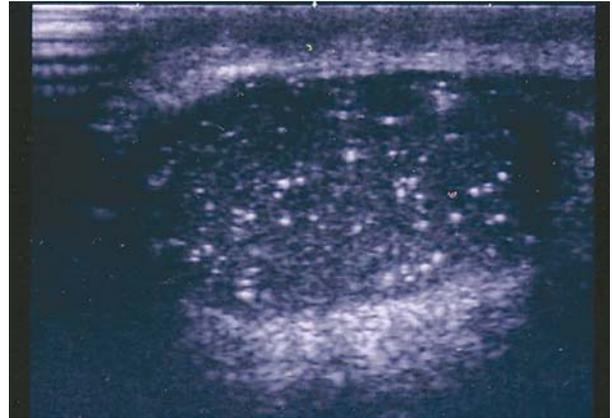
Longitudinal sonogram of the testicle shows numerous, small, echogenic, foci of calcification without posterior shadowing.
